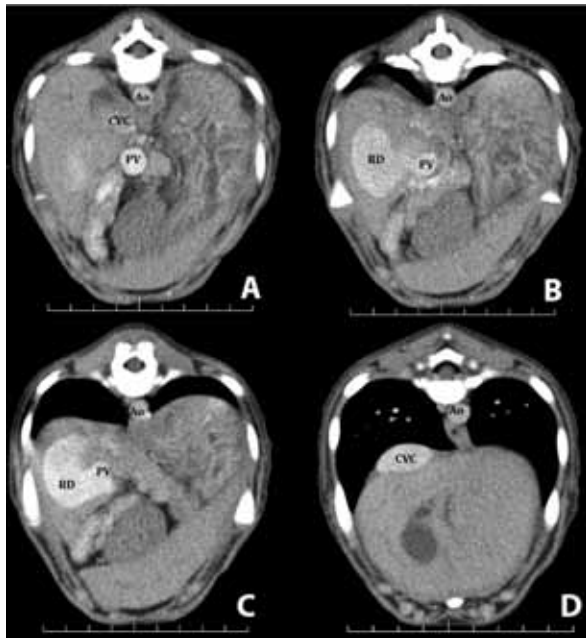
Contrast-enhanced computed tomographic images of the liver obtained during the portal phase (A–D). From caudal to cranial. A right-sided intrahepatic portosystemic shunt (RD) originates from the right hepatic portal vein (PV) and loops into the right liver, forming a wide loop before entering the caudal vena cava (CVC).
